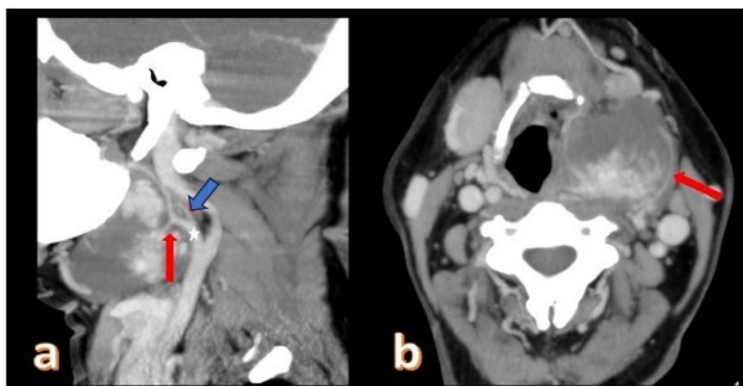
Contrast enhanced CT images (a) sagittal (b) axial plane; mass was encased and supplied by lingual artery (long red arrow); a branch of external carotid artery. Left ascending pharyngeal artery (short red arrow) was seen posteriorly with distal branch which was not well visualised
